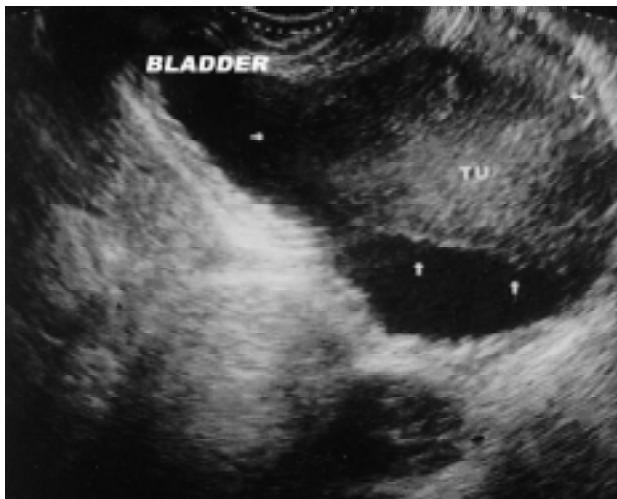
Transvaginal ultrasound revealing an expansive, solid mass, located at the posterior wall, measuring 7.5 x 7.0 x 5.0 cm.
